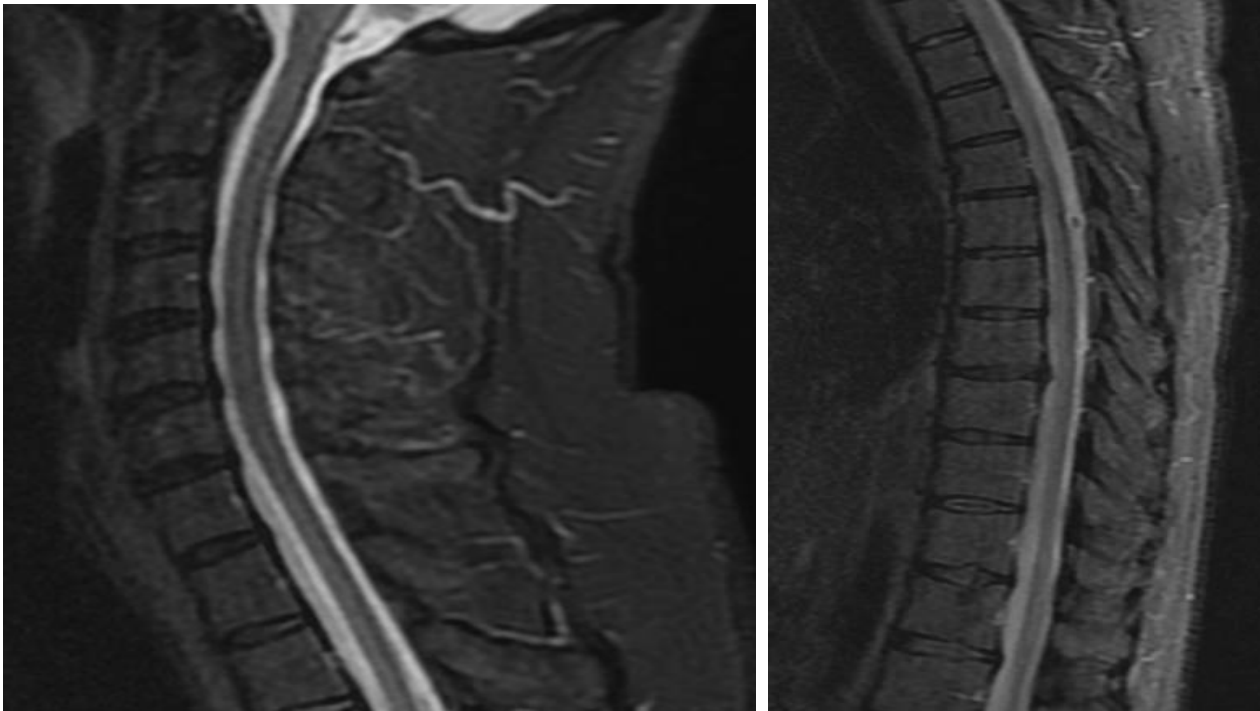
MRI cervical (left) and dorsal (right) spine sagittal plane STIR sequence taken in February 2022. No lesions.
